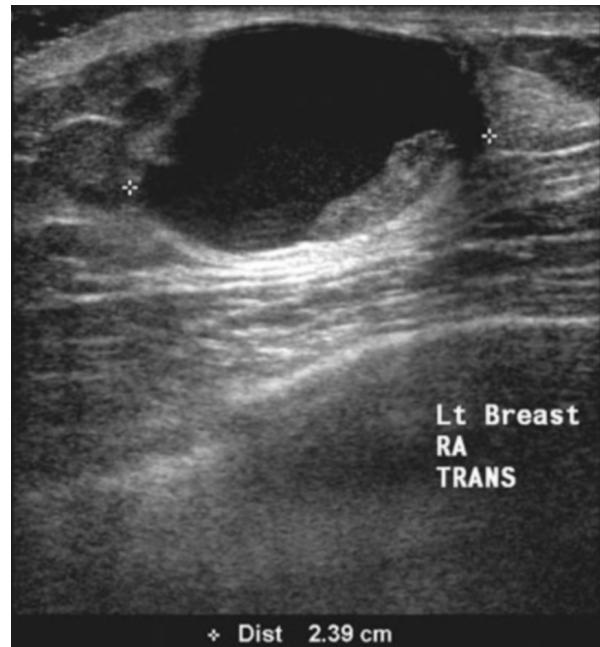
70-year-old man with intracystic papillary carcinoma. At presentation, transverse-axis sonogram of left breast mass demonstrated a complex mass with a solid nodular component.
